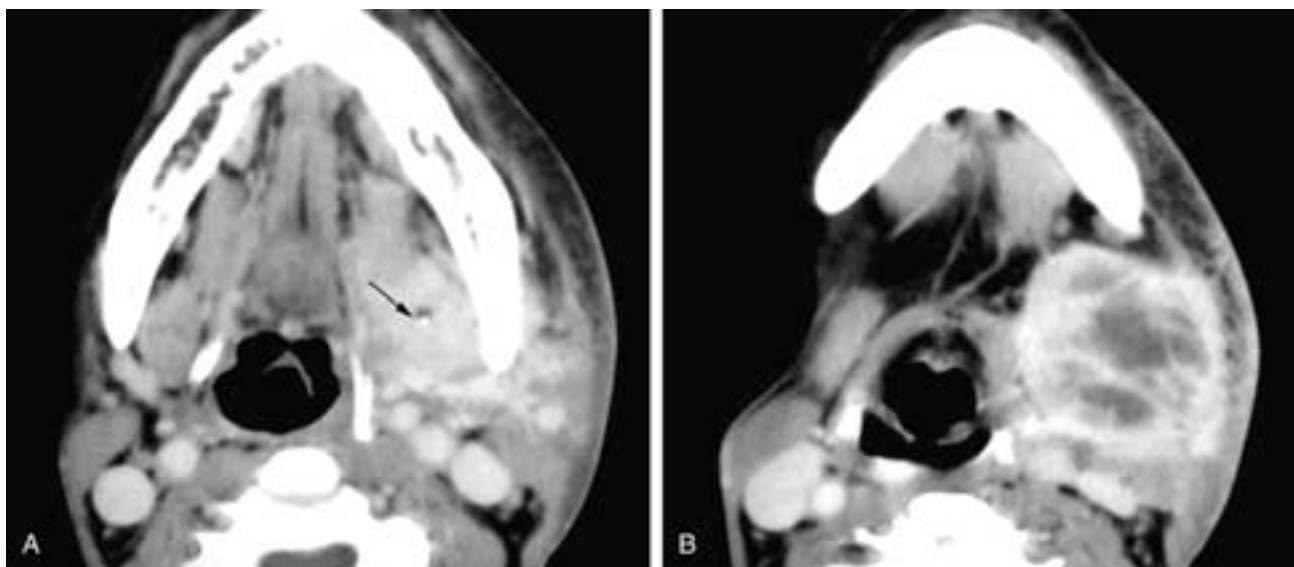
Axial contrast-enhanced CT scans through the floor of mouth (A) and the caudal suprahyoid neck (B). In A, there is an enhancing mass in the region of the left submandibular gland. A small calculus is present near the hilum of the gland (*arrow*), and the process extends beyond the gland into the adjacent floor of the mouth and the submandibular triangle. In B, an abscess is seen in the submandibular triangle, with adjacent thickening of the platysma muscle and thickening and injection of the overlying subcutaneous fat and skin. This abscess arose in the acutely obstructed submandibular gland and spread over the back of the mylohyoid muscle into the submandibular triangle of the neck. Such an abscess from an acutely obstructed gland is unusual. This patient turned out to be HIV positive, which accounted for the rapid spread of the infection.
